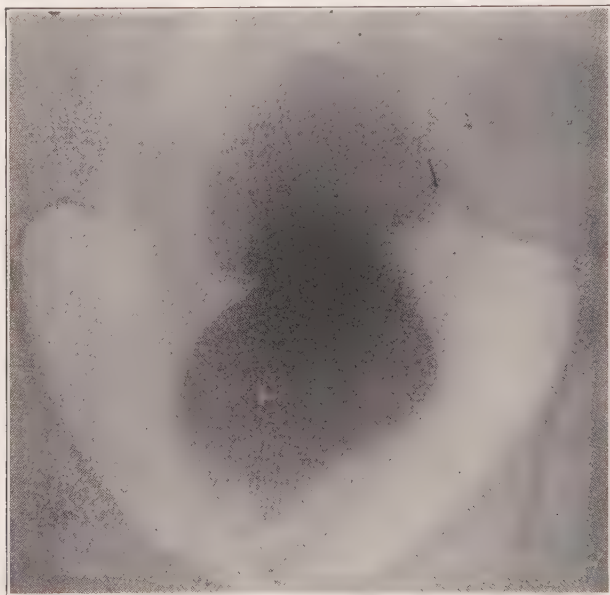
ROENTGENOGRAM OF NORMAL RECTUM (R).
